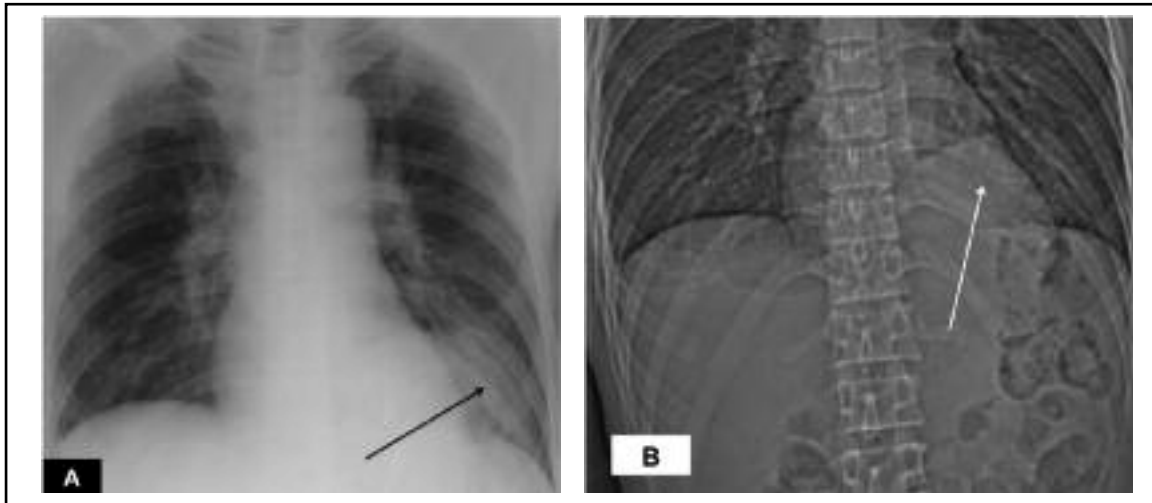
(A) Postero-anterior chest radiograph showed well-defined focal opacity at left lower zone (black arrow). (B) Scanogram from CT scan of this patient clearly demonstrated focal eventration of the left hemidiaphragm (white arrow).
